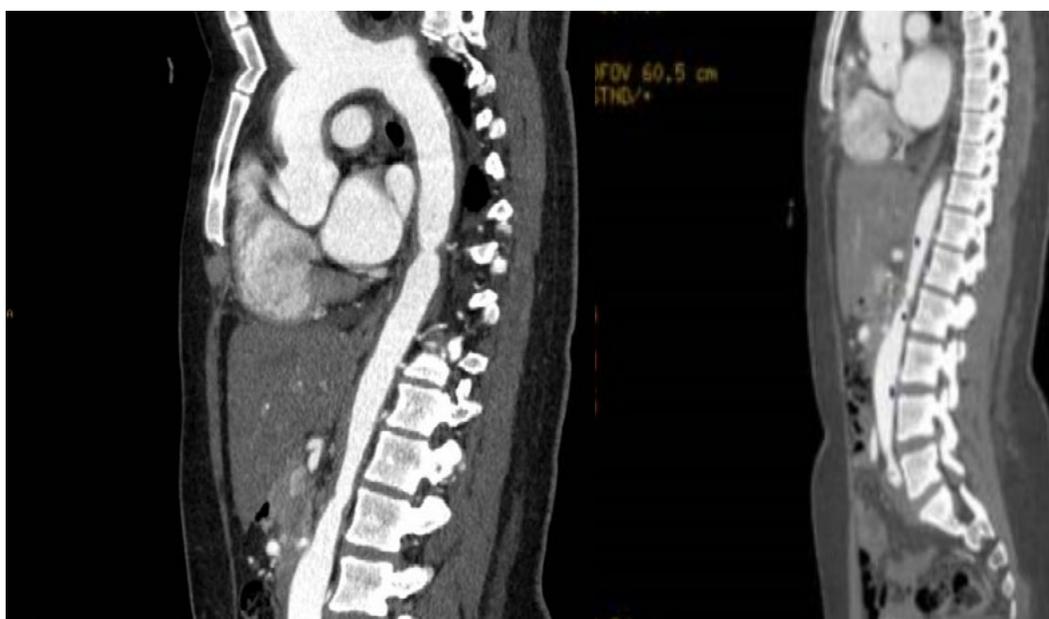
Sagittal contrast-enhanced CT angiography images showing large-vessel involvement of the thoracoabdominal aorta, consistent with inflammatory changes in Takayasu arteritis.
